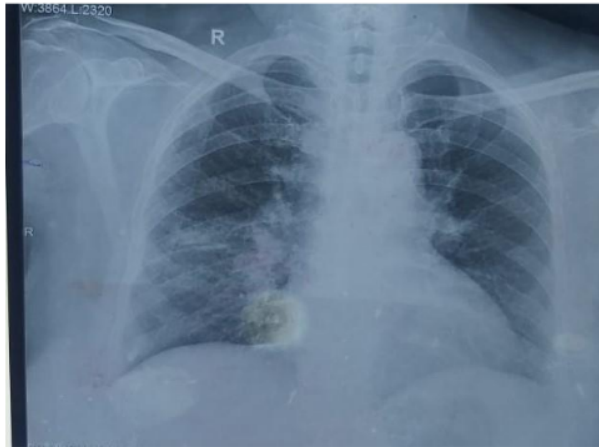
Initial Chest X-Ray Findings
